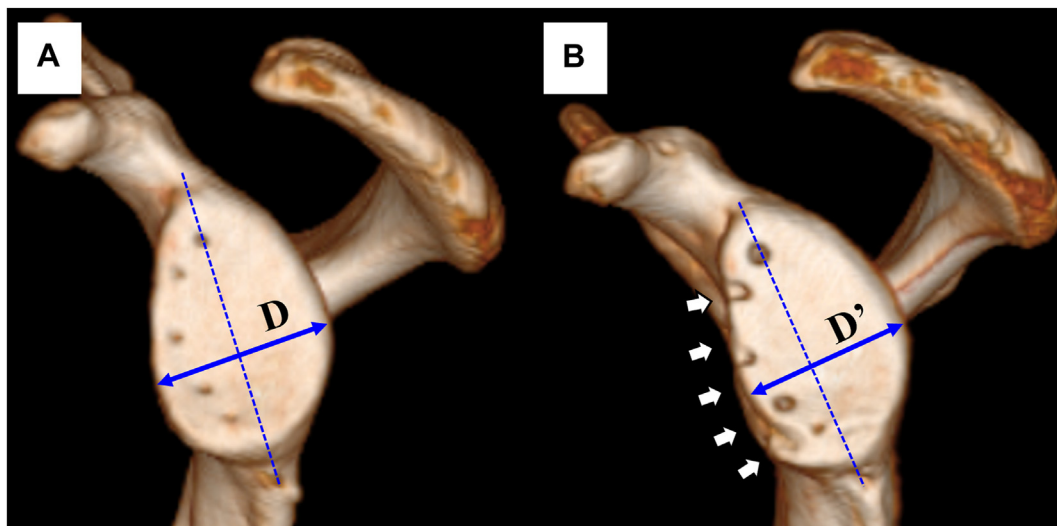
Measurement of glenoid width change by 3-dimensional computed tomography. (A). Baseline computed tomography (CT) scan (1 day postoperatively): Line D represents the maximum width perpendicular to the long axis of the glenoid. (B). Second CT scan (3 months postoperatively): White arrows indicate anterior rim resorption, and line D' indicates the maximum width perpendicular to the long axis of the glenoid at this time. The percentage change in glenoid width ($\Delta\%$) was calculated as follows: $\Delta\% = (1 - (D'/D)) \times 100$.
